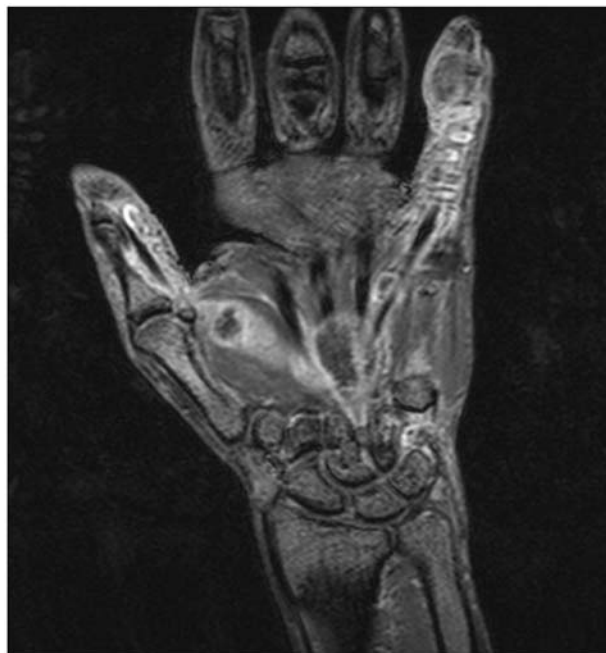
MR image of tuberculous tenosynovitis involving the thumb and small fingers. Note the extensions to the wrist.
